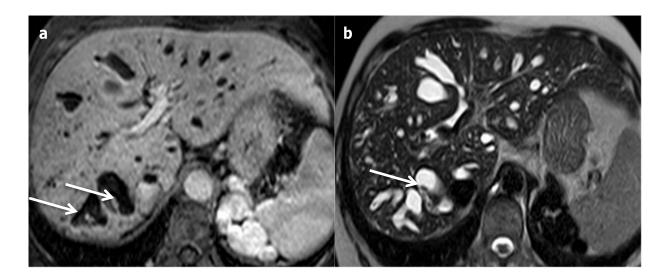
Caroli syndrome in a 53-year-old female patient. (a) Axial magnetic resonance imaging at portal-venous-phase shows peripheric fusiform dilated bile duct, hyperintense at axial T2-weighted magnetic resonance imaging (b), with the specific "central dot-sign" (arrows). Note the presence of spleno-renal shunts due to portal hypertension.
